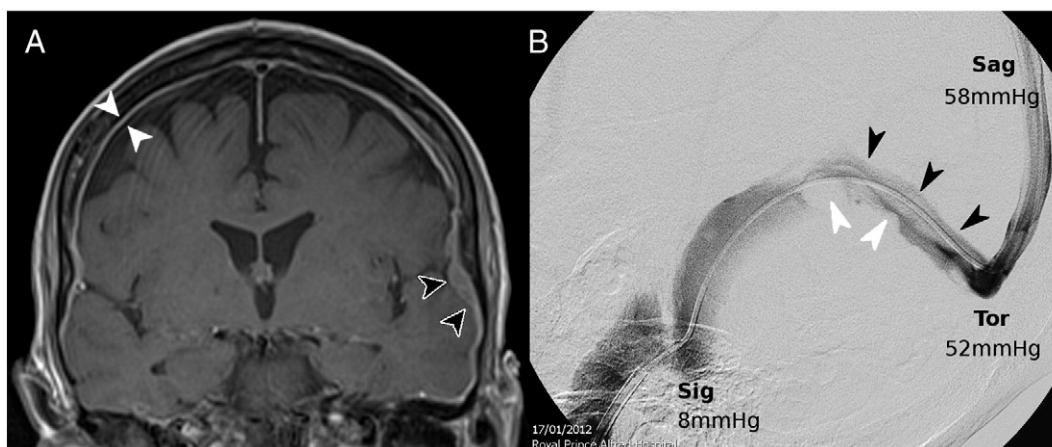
(A) Contrast enhanced coronal T1 MRI of patient [1] with malignant pachymeningitis (dural metastases) showing a metastatic mass in the dura over the left temporal lobe (black arrowheads) as well as diffuse pachymeningeal enhancement (white arrowheads). (B) Catheter venogram of patient [1] showing multiple intrinsic lesions in the dominant right transverse sinus (white arrowheads) as well as extrinsic compression (black arrowheads) producing a pressure of 58 mm Hg (= 760 mm H₂O) in the superior sagittal sinus (Sag) with a gradient of 46 mm Hg from the torcula (Tor) to the sigmoid sinus (Sig).
